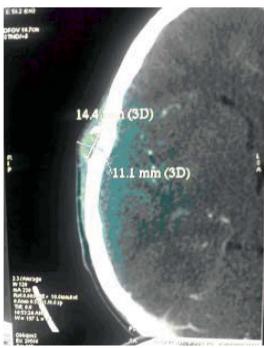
Contrast CT scan - axial section showing homogeneous enhancement of the lesion located in the ® high temporal region. Note the intact inner table and interruption of the outer table of the skull.
